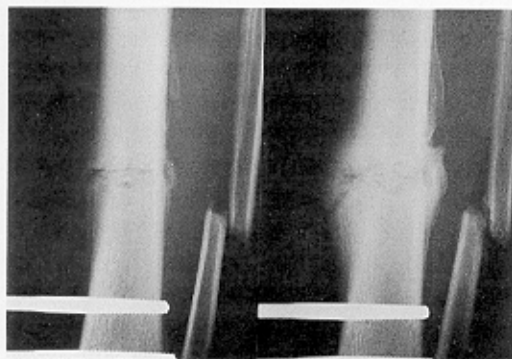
A transverse diaphyseal tibial fracture stabilized by an Orthofix unilateral external fixator. The radiographs show a fracture line extending from the interfragmentary gap to the peripheral callus tissue at the medial surface adjacent to the fixator, at (left) 8 weeks and at (right) 18 weeks.
